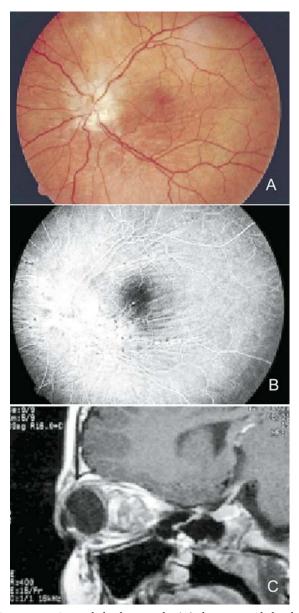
Optic disk photographs (A) show optic disk edema and choroidal folds that are seen better on the fluorescein angiogram (B) as alternating light (hyperfluorescent) and dark (hypofluorescent) lines. (C) Sagittal T1-weighted MR imaging shows an orbital mass compressing the posterior globe.
